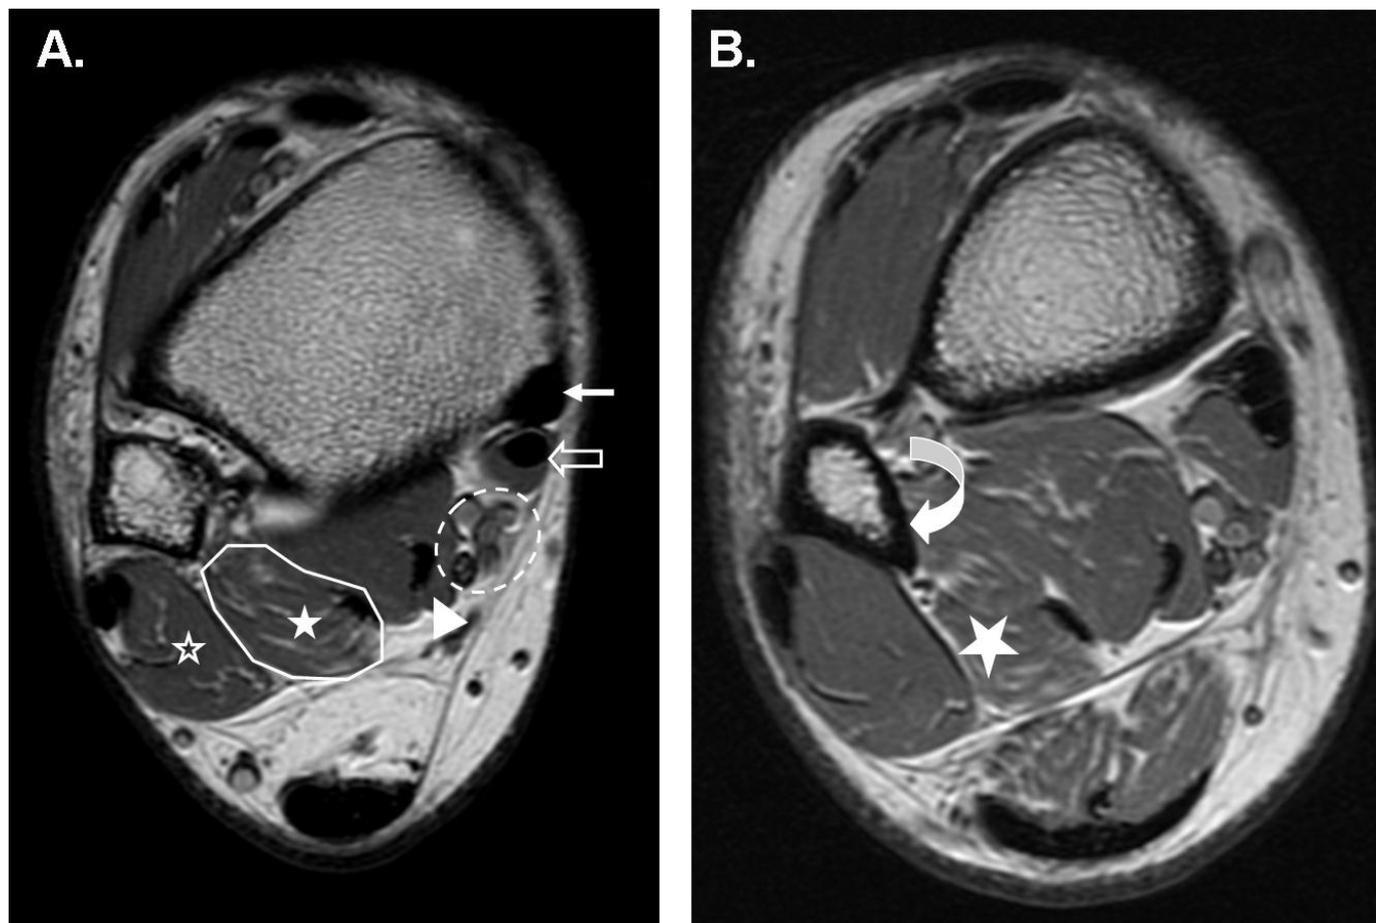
68-year-old male with ankle pain and an accessory peroneocalcaneus internus muscle. A. Axial non-contrast proton density MR image of the right ankle near the level of the syndesmosis (3T GE clinical scanner, GE Healthcare, WI, USA; TR=3707, TE= 29, ETL=8, matrix 384x256, FOV=14cm, slice thickness/spacing=4/0mm). The accessory muscle and tendon is outlined in white with the muscle portion marked with a white star. This accessory muscle is situated between the flexor hallucis longus muscle (arrowhead) and the peroneus brevis muscle (open star). Tibialis posterior tendon (white arrow). Flexor digitorum longus tendon (open arrow). Tibial neurovascular bundle (outlined dashed oval). B. A more proximal non-contrast axial proton density MR image from the same sequence again demonstrates the accessory peroneocalcaneus internus muscle (star). The curved arrow highlights a portion of the muscular origin of the peroneocalcaneus internus from the medial margin of the distal fibula.
